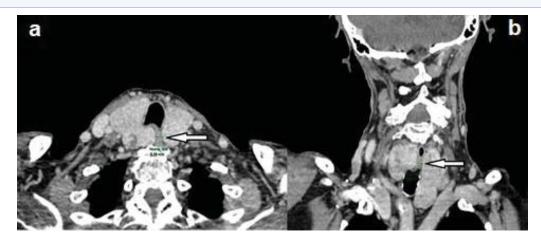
Contrast-enhanced neck CT, axial (a) and coronal (b), showing (arrow) esophageal extrinsic compression and reduced diameter prior to RAI (minimum diameter estimated at 6.0 mm).
